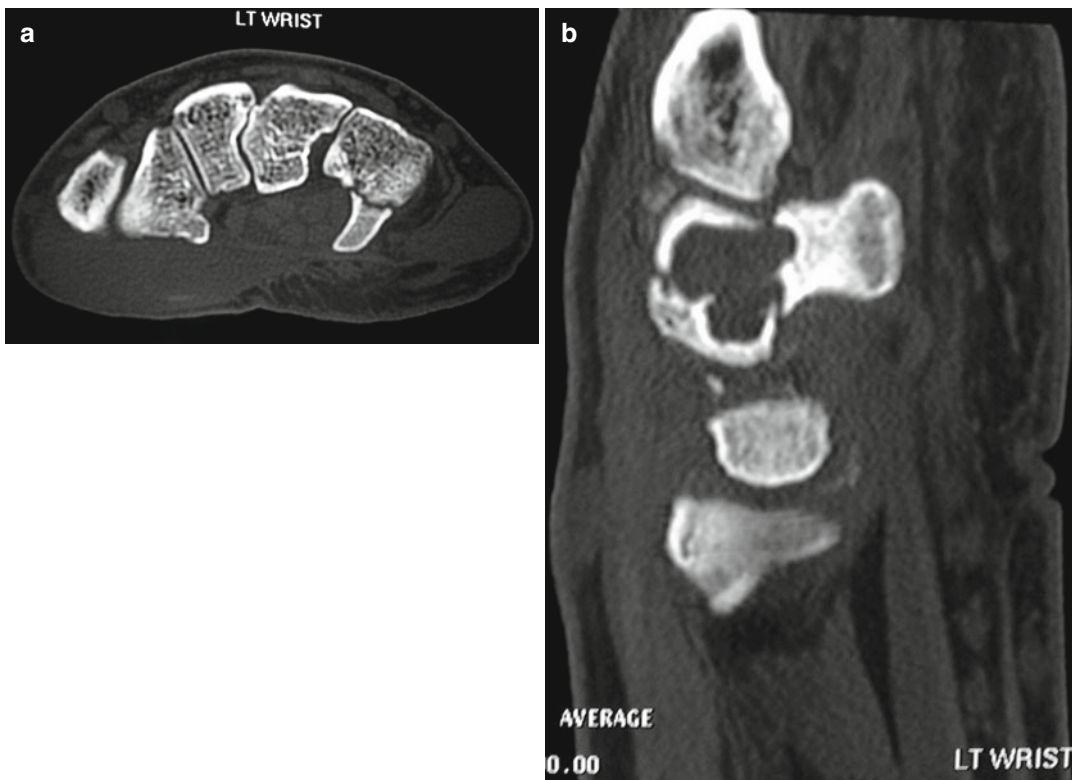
Demonstrating CT images of a hook of hamate fracture with associated cyst (Images provided from Adam Watts, with permission)
